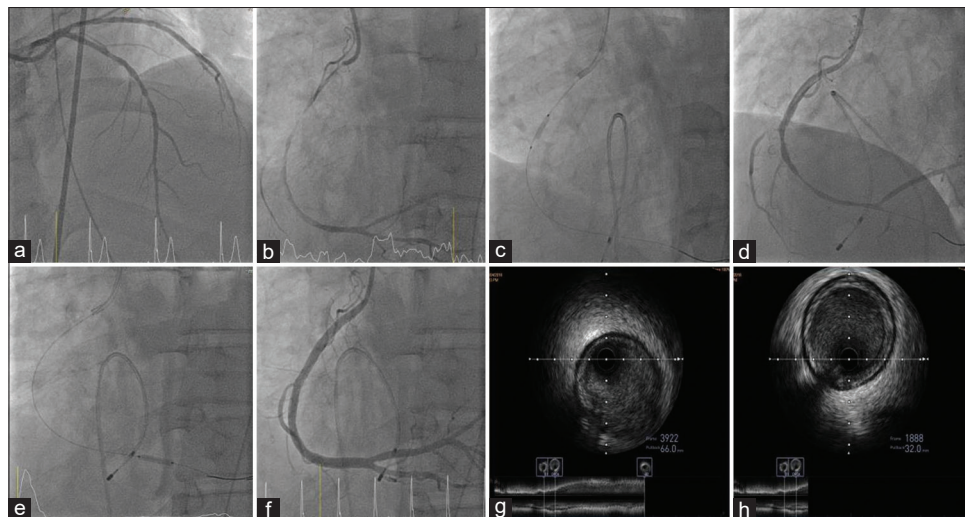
Coronary angiogram images. (a) Left anterior descending artery and left circumflex artery (AP cranial). (b) Right coronary artery (LAO). (c) Balloon angioplasty of the proximal right coronary artery lesion (LAO). (d) Right coronary artery post-angioplasty with new stenoses appearing in the distal right coronary artery and right posterior descending artery (LAO cranial). (e) Balloon angioplasty of the distal right coronary artery lesion (LAO). (f) Right coronary artery post-angioplasty (LAO) (given intracoronary glyceryl trinitrate 200 mcg before the final shot). (g) Intravascular ultrasound of the proximal right coronary artery. (h) Intravascular ultrasound of the distal right coronary artery. AP = anteroposterior view, LAO = left antero-oblique view.
